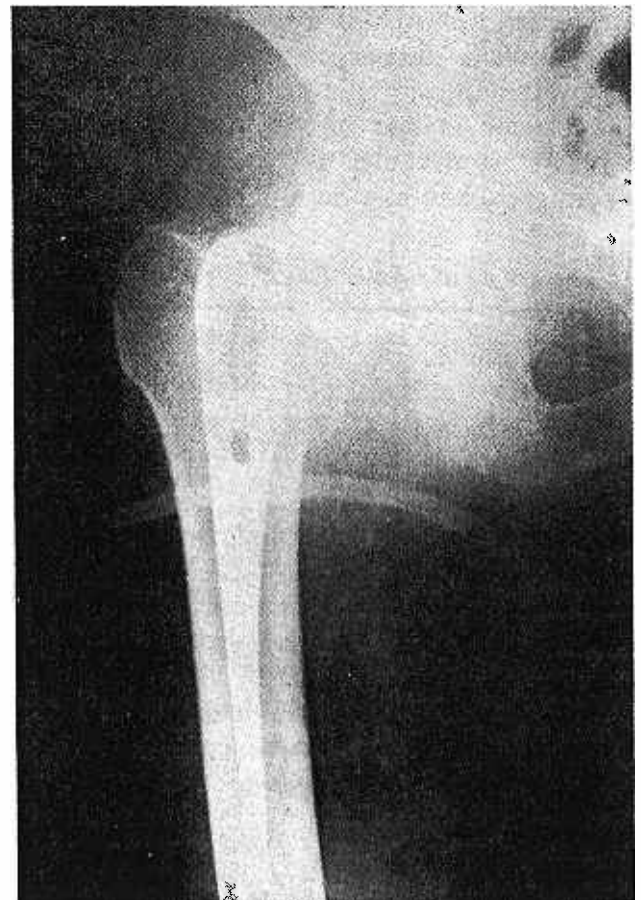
X-rays of Y.M.K., first post-operative day.
